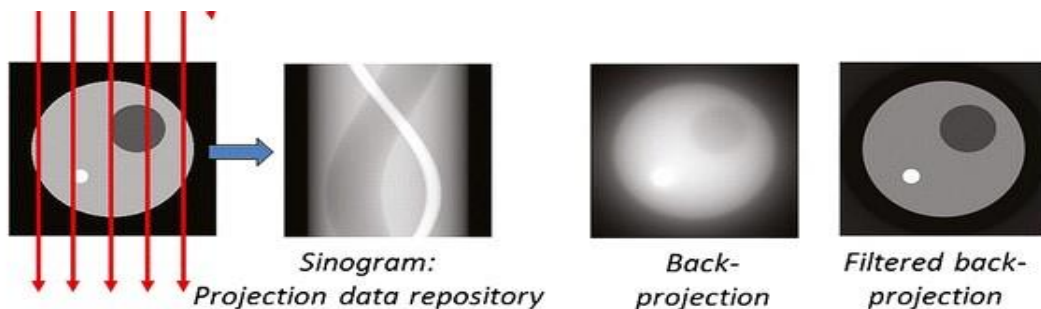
Image acquisition in CT from springerlink
